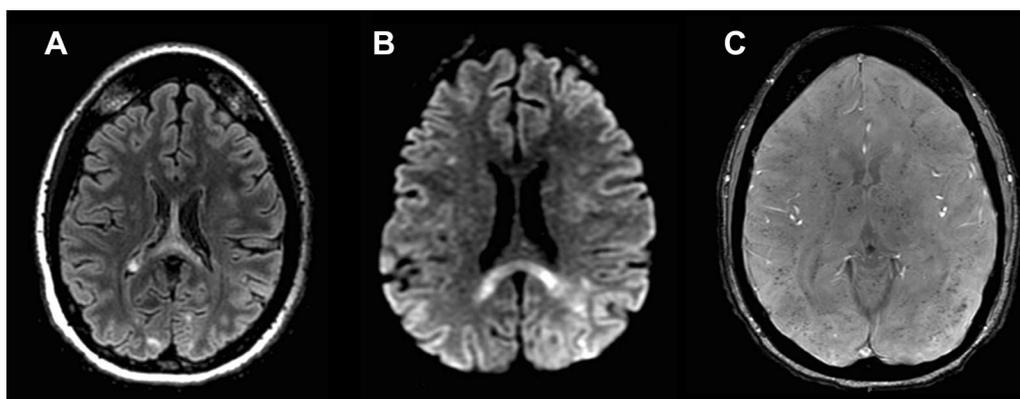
MRI after extracorporeal membrane oxygenation withdrawal. a axial fluid-attenuated inversion recovery (FLAIR) imaging showing hypersignal involving the splenium of the corpus callosum. b diffusion-weighted imaging (DWI) showing hyperintensity involving the splenium of the corpus callosum with low apparent diffusion coefficient (ADC). c Susceptibility weighted magnetic resonance sequences (SWAN) showing widespread subcortical microbleeds in the white matter, predominating in subcortical *U* fibers
